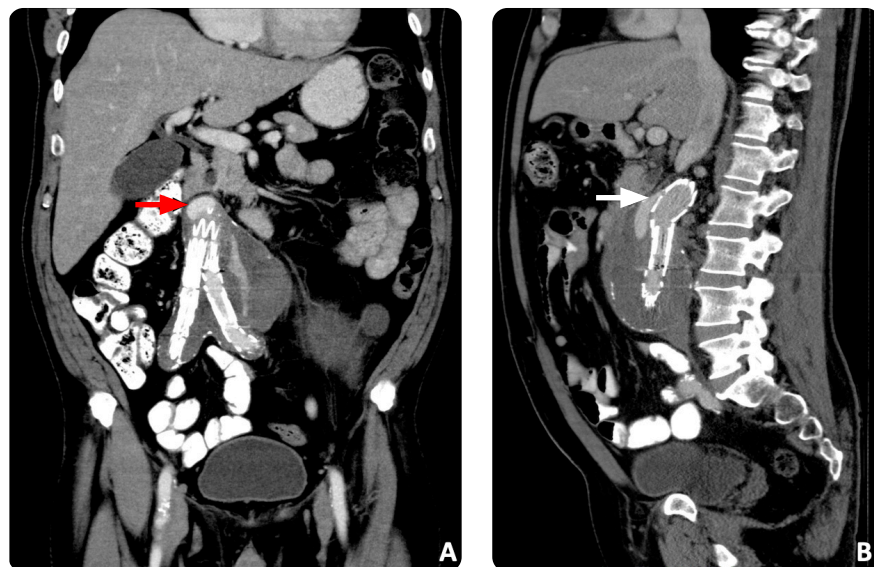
Abdominal CT with contrast medium: a) coronal section and b) sagittal section. The arrows indicate the leakage of contrast material between the aortic wall and the prosthesis, corresponding to a type Ia endoleak.
